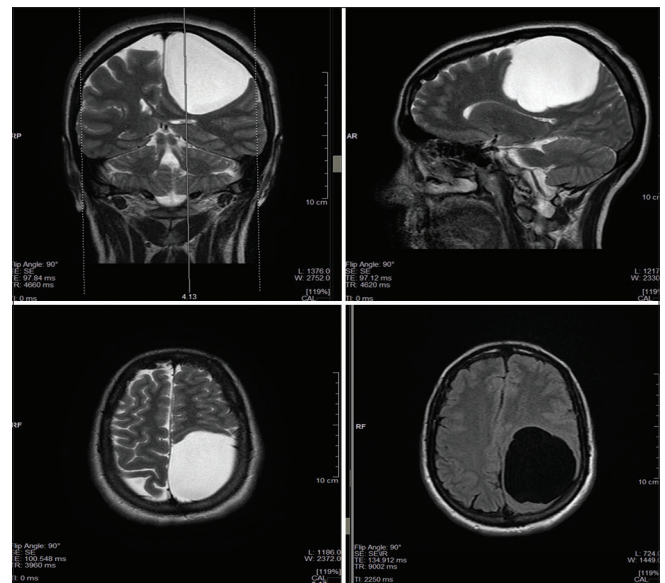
Preoperative magnetic resonance imaging scans show an increase in volume of the cyst lesion
